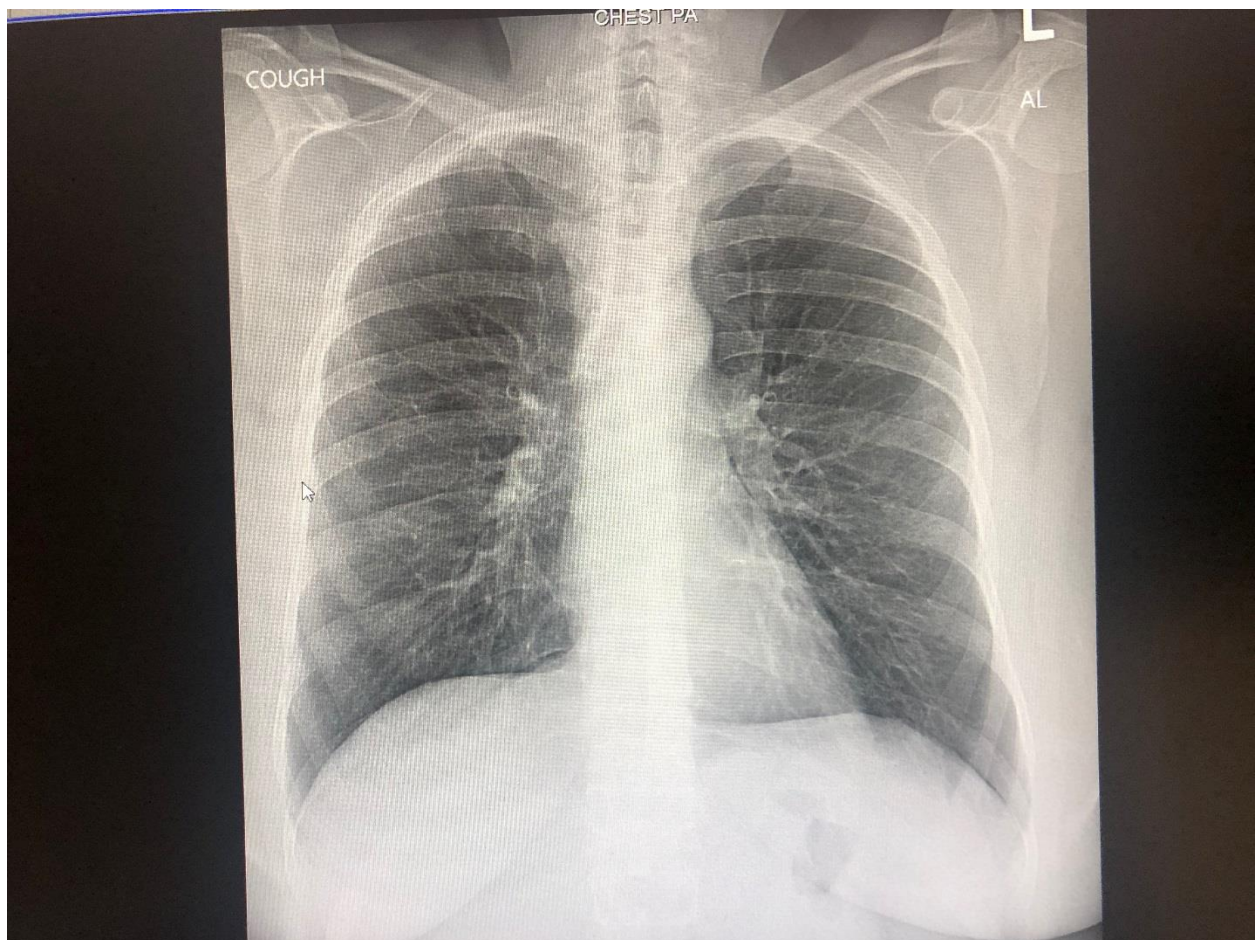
Day #7, chest x-ray normal
